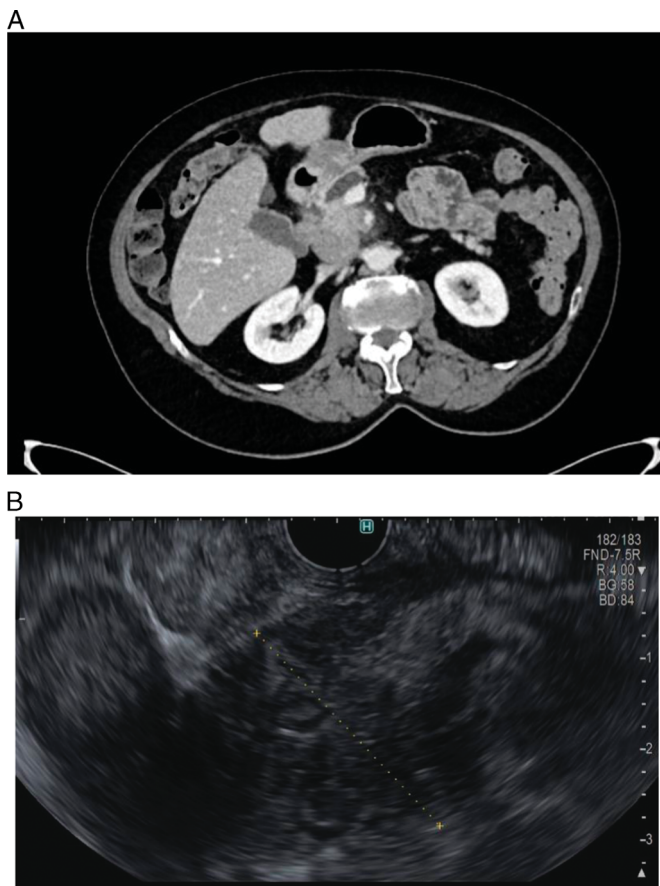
A 64-year-old woman presented with central abdominal discomfort and underwent a CT (A), which demonstrated an ill-defined mass in the head of pancreas causing an abrupt cutoff of the pancreatic duct and common bile duct. She underwent EUS (B), which demonstrated a poorly demarcated, heterogeneous soft tissue mass within the head of pancreas. EUS-FNA confirmed the diagnosis of MINENs.
